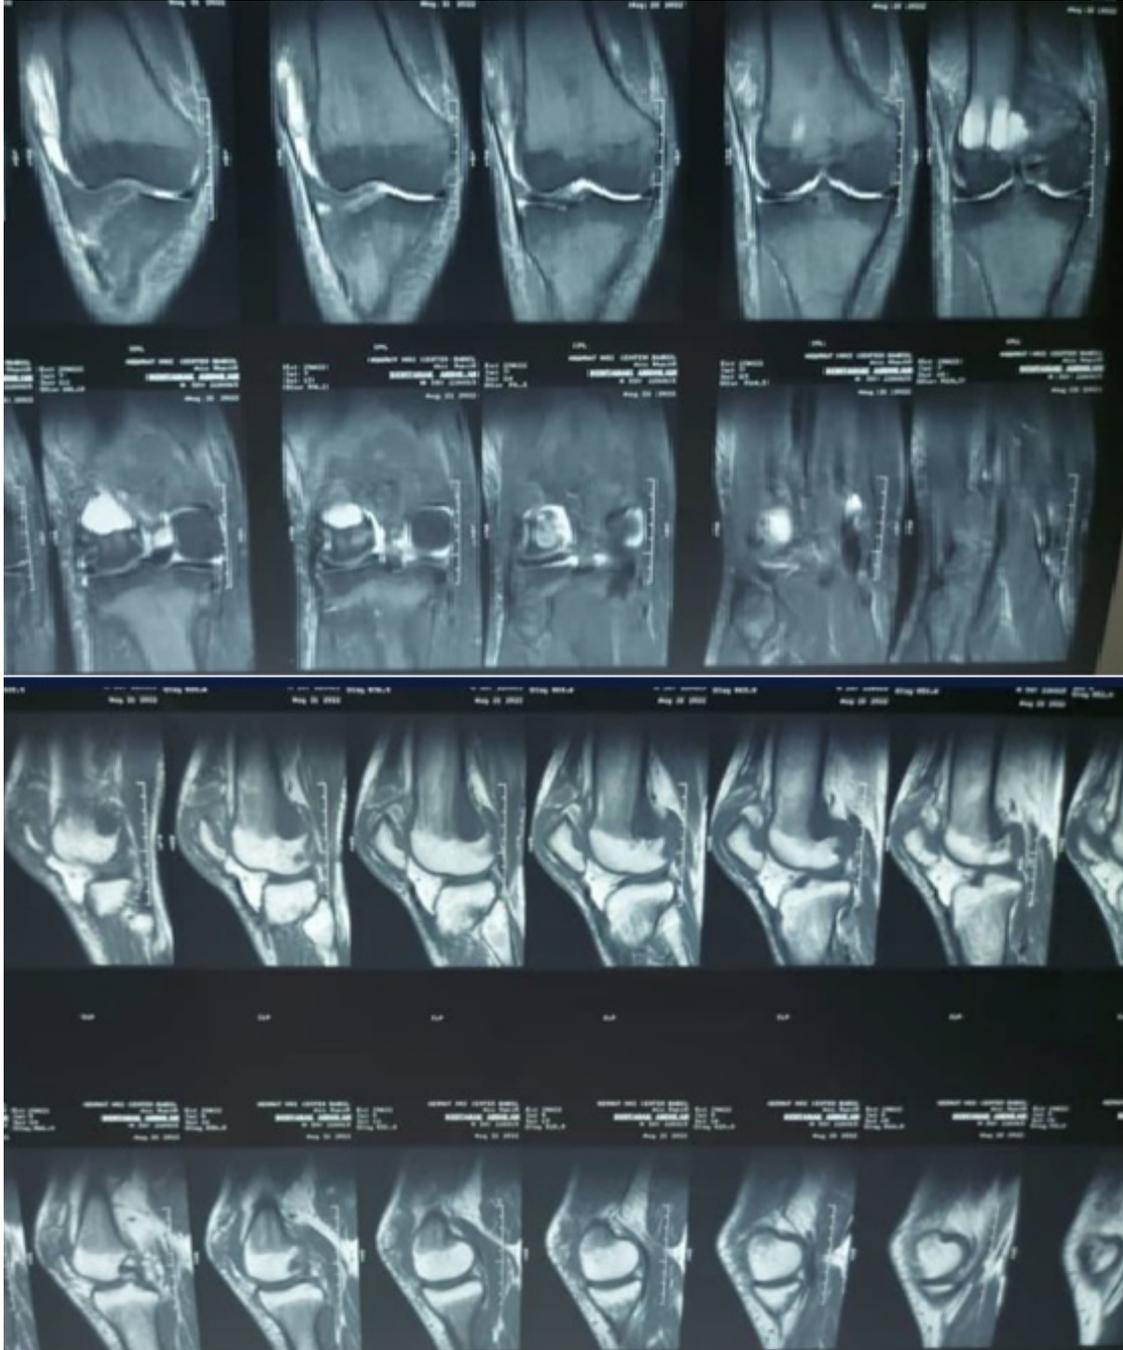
Preoperative MRI of the patient.
